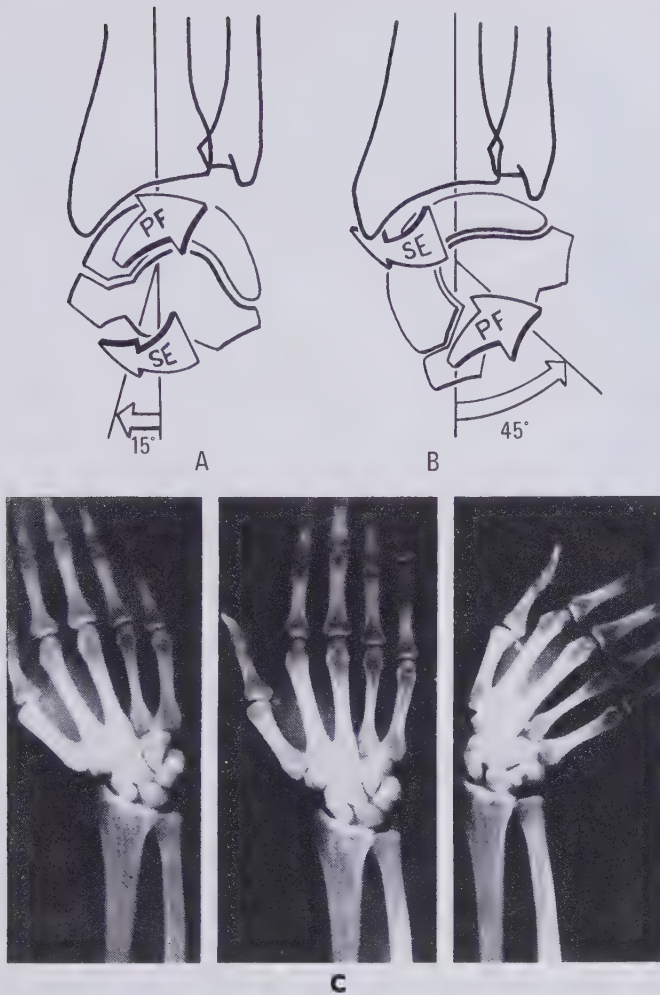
Lateral movements of the wrist. Abduction (radial inclination) and adduction (ulnar inclination) of the wrist consist of movements occurring at the radiocarpal joint and midcarpal joints. *A*, During abduction, the proximal row also executes a pronation-flexion (PF) and the distal row a supination-extension (SE) movement. *B*, During adduction, the movements are in reverse: supination-extension (SE) for the proximal row and pronation-flexion (PF) for the distal row. In both instances these accessory movements cancel each other out. Note that the ulnar inclination is three times the radial inclination. *C*, X-ray views showing complete radial and ulnar inclination. (*B* after Kapandji, A. I.: *Physiologie Articulaires*. Paris, Librairie Maloine, 1963, Vol. 1.)
